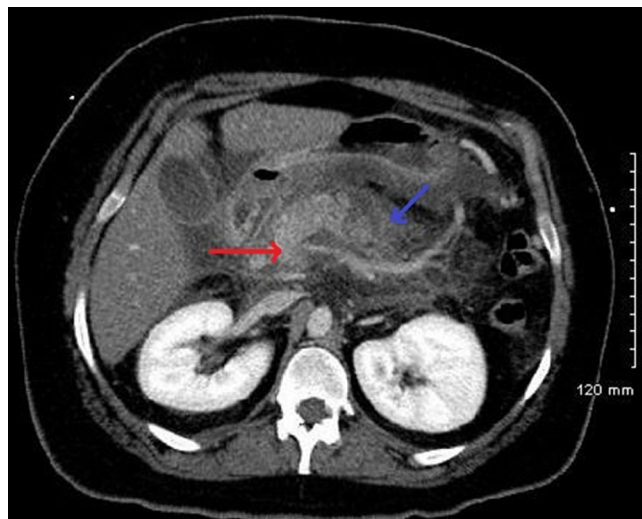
CT of the abdomen demonstrating pancreatitis with patchy necrosis (red arrow) and peripancreatic edema and indistinct pancreatic borders (blue arrow).
